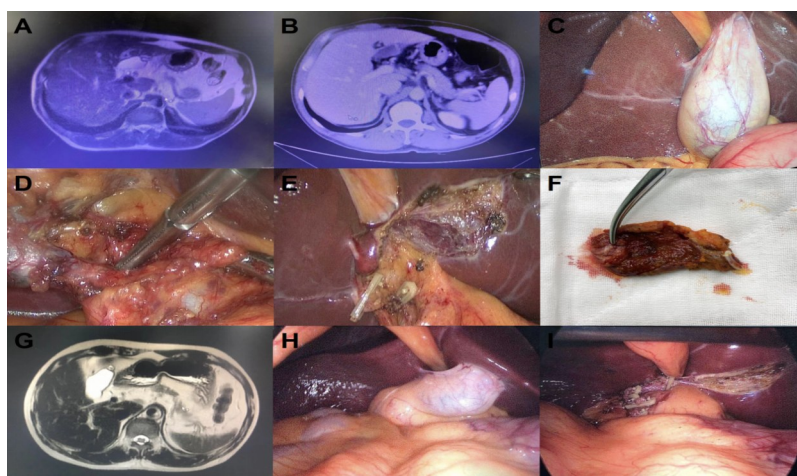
Imaging and Intraoperative Findings of Left-Sided Gallbladder in Laparoscopic Cholecystectomy. (A) MRI showing a possible left-sided gallbladder. (B) CT showing the gallbladder located to the left of the round ligament of the liver. (C) Laparoscopic view of the left-sided gallbladder. (D) Cystic duct and cystic artery of the left-sided gallbladder. (E) Liver surface exposed after gallbladder removal. (F) A polyp approximately 1.2 cm found inside the gallbladder. (G) Preoperative MRI findings. (H) Gallbladder infundibulum crossing anterior to the hepatic hilum. (I) Liver surface exposed after gallbladder removal.
